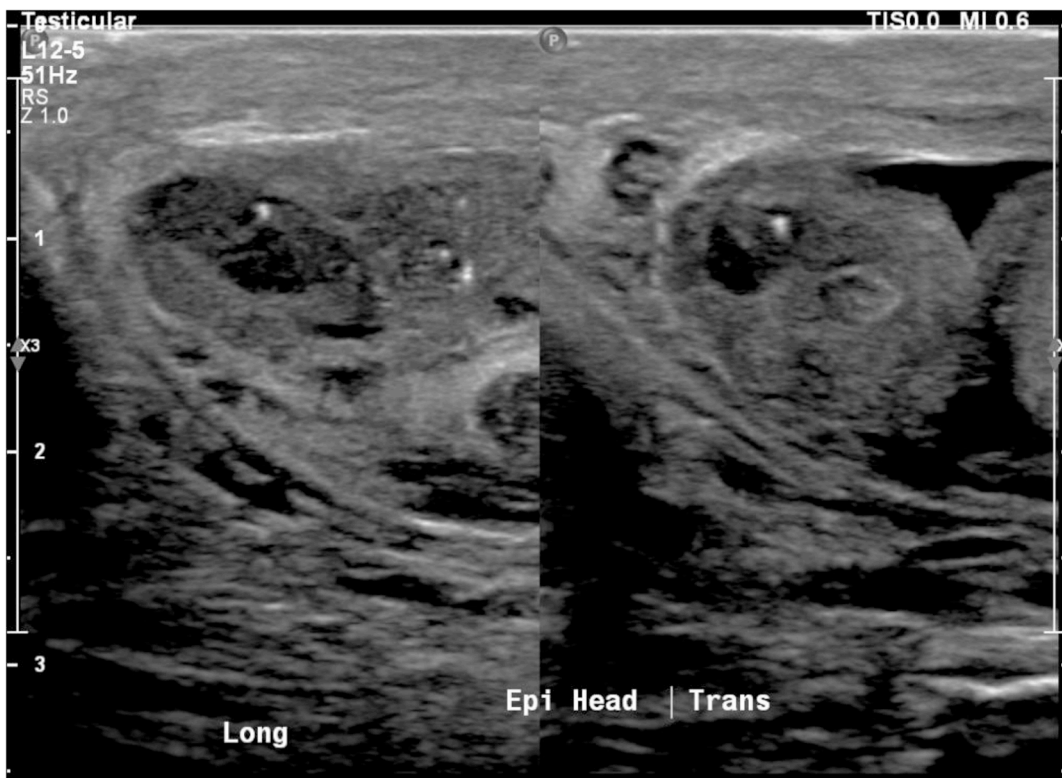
Ultrasound image of Epididymal Head containing evidence of Filariasis.
